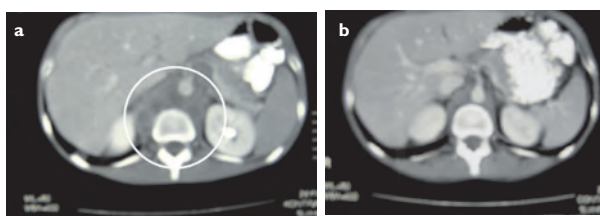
Testicular cancer. Abdominal computed tomography scan with enlarged para-aortic lymph node mass, (a) pre- and (b) post chemotherapy, and (c) neoplasia of the right testis.
